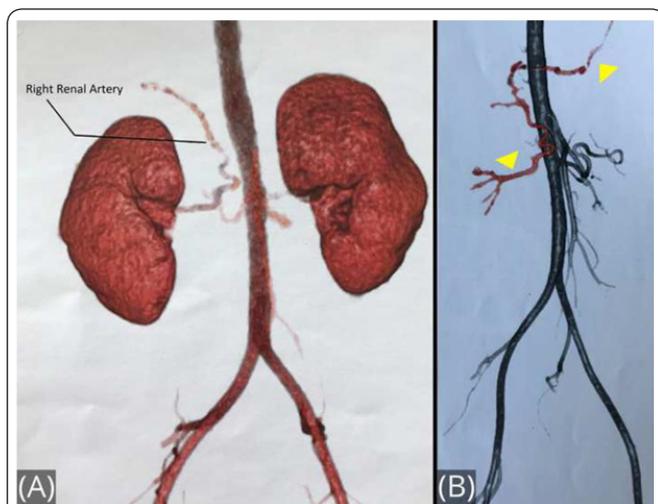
Preoperative (A) computed tomographic (CT) aortogram 3-dimensional reconstruction showing that the right renal artery does not originate from the abdominal aorta. (B) Highlighted right renal artery (arrowhead) unconventional cephalic path.
